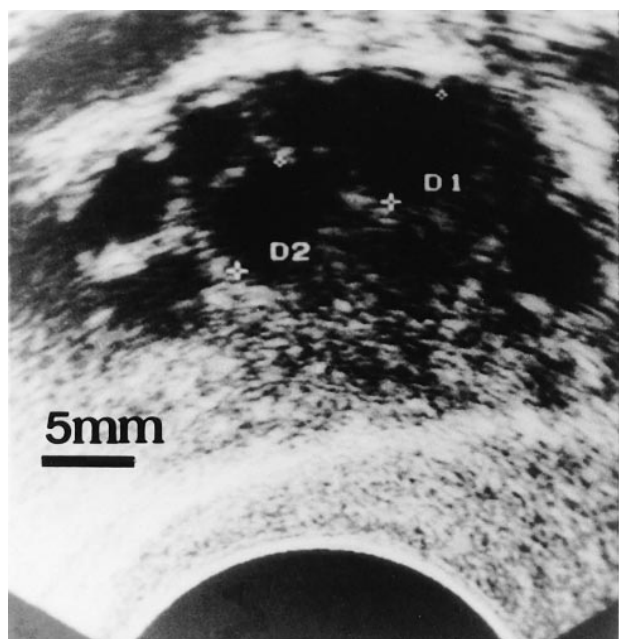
Ultrasonography of the ovaries. Both ovaries exhibited the same sonographic aspect. Note that various follicles of 3–5 mm are seen. A scale (5 mm) is represented. D1 and D2 indicate two of the largest follicles.
